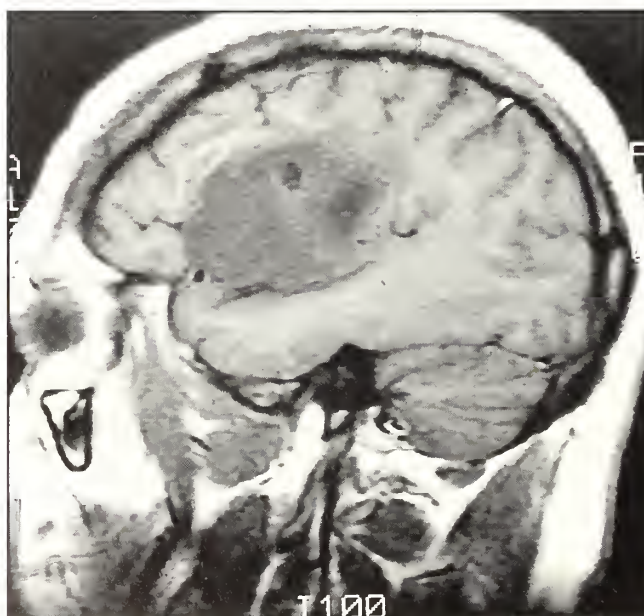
MRI scan of the brain. T-1 weighted parasagittal section. This scan shows the lesion as it relates to the surface sulcal pattern, using the orientation seen by the surgeon during surgery (see *Figure 3*).
